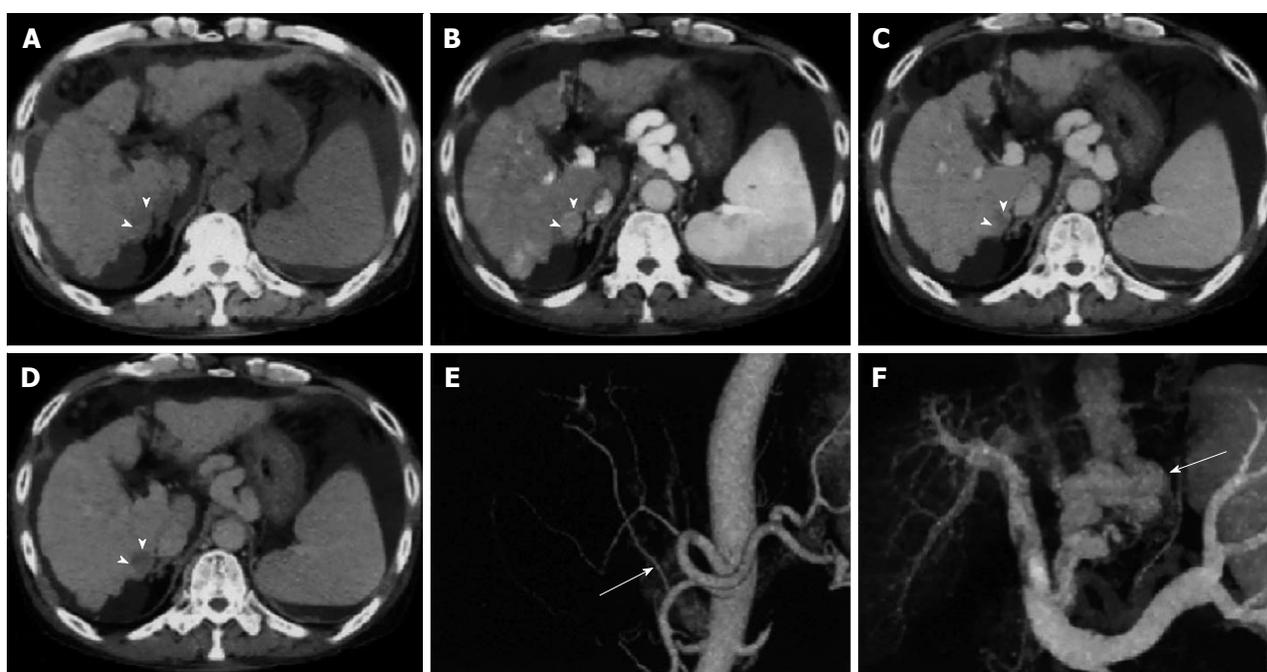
Multi-detector computed tomography of hepatocellular carcinoma. A: Pre-contrast; B: Late arterial phase; C: Portal venous phase; D: Equilibrium phase dynamic multi-detector computed tomography images. The hepatocellular carcinoma (arrowheads) is visualised as an enhanced nodule in the late arterial phase and as a hypo-attenuated nodule in the equilibrium phase; E: Three-dimensional computed tomography angiography of hepatic arteries shows that the right hepatic artery branches (arrow in E) from the superior mesenteric artery; F: The portal venous system with creation of varices (arrow)^[66].
